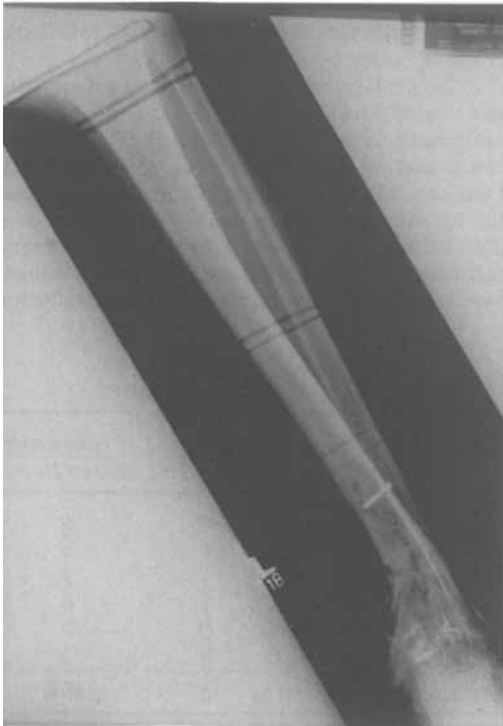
Radiograph of tibia before surgery.
